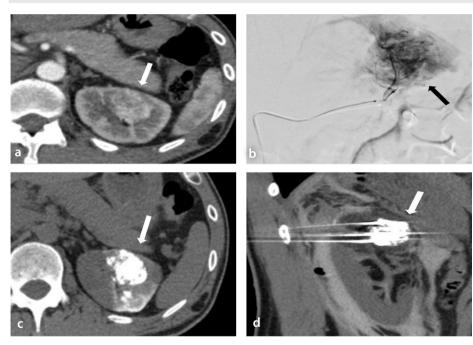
Cryoablation for a sporadic renal cell carcinoma of a 47-year-old man with preoperative lipiodol marking. (a) Contrast-enhanced CT showed an endophytic 3.3-cm mass at the ventral side of the left kidney (arrow). (b) Digital subtraction angiography from the upper branch of the left renal artery showed a hypervascular lesion representing the renal mass (arrow). (c) CT after transarterial lipiodol marking showed well-infused lipiodol in the renal mass (arrow). (d) CT-guided cryoablation was performed on the lipiodol-infused mass (arrow) using cryoprobes. After 4 years of follow-up, there was no recurrence, the Δ eGFR was 2, there was no decrease in CKD grade, and there were no grade 3 or higher complications. CT, computed tomography; eGFR, estimated glomerular filtration rate; CKD, chronic kidney disease.
